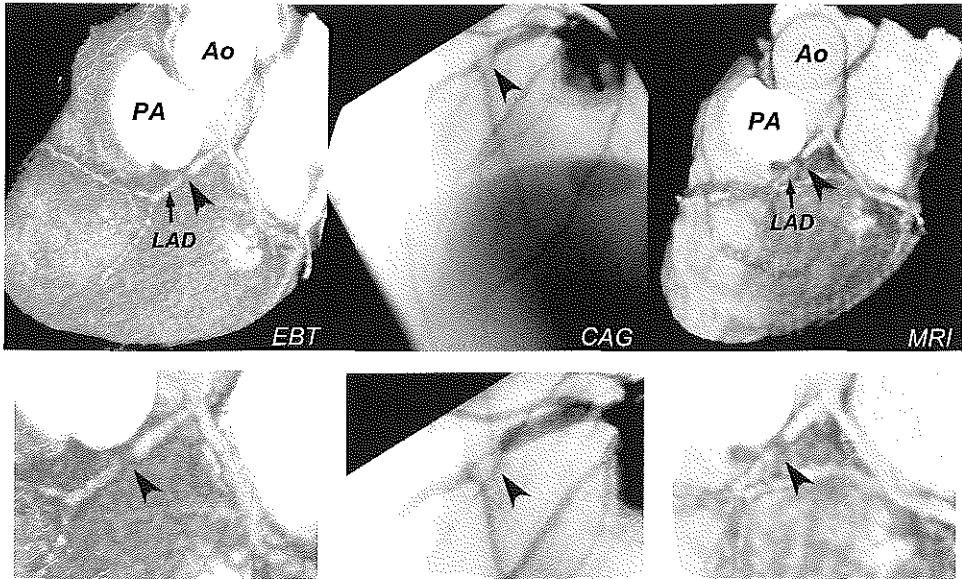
Patient with a left anterior descending coronary artery LAD stenosis (arrow head) detected by conventional selective coronary angiography (middle image). Both EBT (left image) and MRI (right image) were able to detect this stenosis non-invasively. Ao = Aorta, PA = Pulmonary artery.
